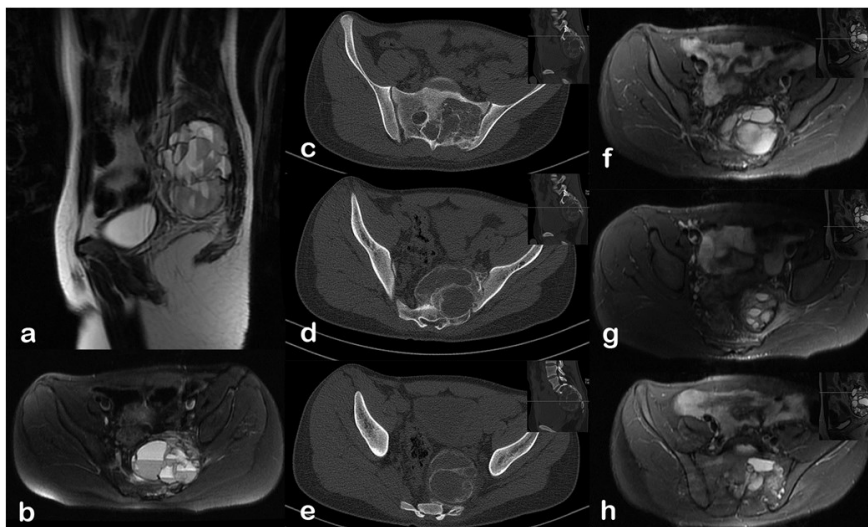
Male, 16 years old. MRI showed fluid-fluid levels on left side of his sacrum, suggesting ABC (a, b). After SAE, tumor growth was controlled, as seen on last follow up CT and MRI (c to h).
